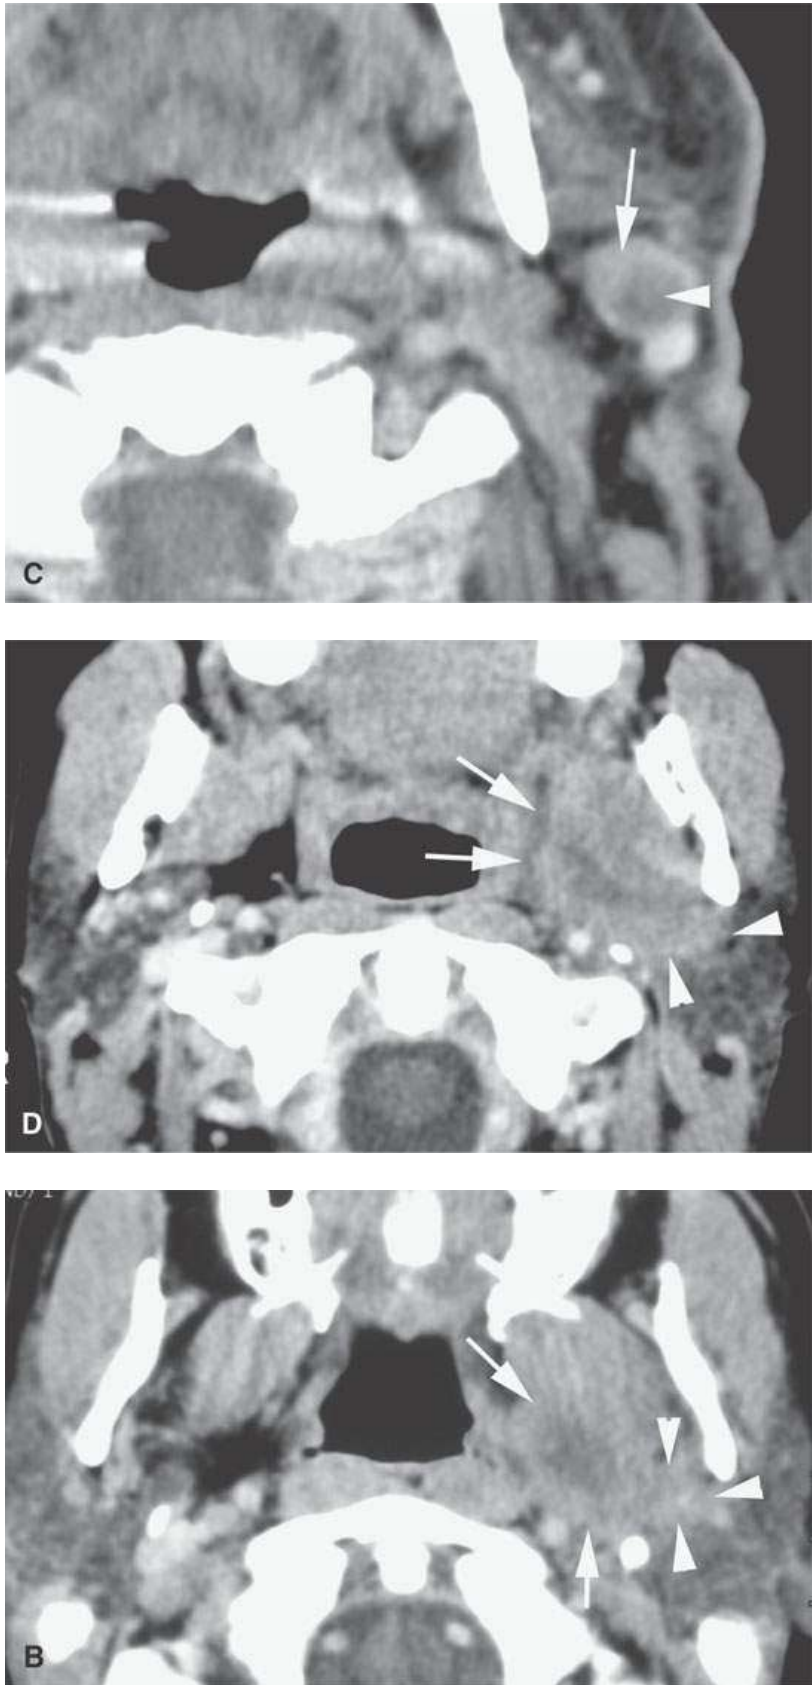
Three patients with carcinoma arising from a benign mixed tumor (carcinoma ex pleomorphic). A: Contrast-enhanced T1-weighted images showing the multifocal cancer with aggressive margins in the deep portion of the parotid gland and adjacent parapharyngeal space. B, C: Contrast-enhanced computed tomography (CECT) showing the parotid-origin cancer (C) and related node (arrow in D) containing a metastatic deposit. D, E: CECT of a cancer arising from a parapharyngeal BMT; the parapharyngeal fat is infiltrated (arrows), and the lateral margin of the mass suggests locally aggressive behavior (arrowheads) (D); the otherwise well-circumscribed mass (arrows) invades laterally along the pterygoid plexus (arrowheads) (E).
